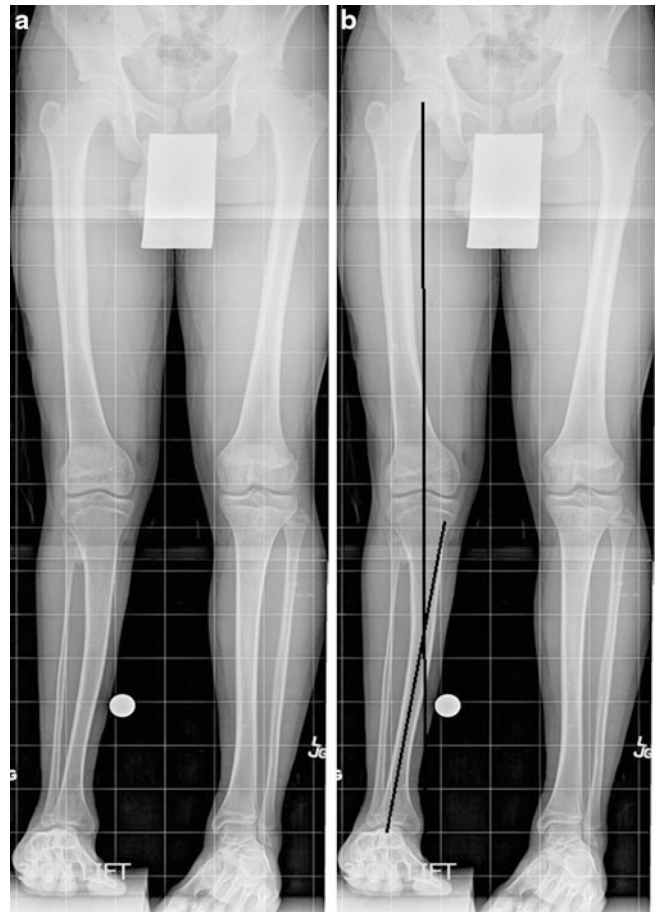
(a) Bipedal erect leg X-ray showing valgus deformity of the tibia, LLD of 3.5 cm, and a short hypoplastic fibula. (b) Surgical planning to determine location of osteotomy and the magnitude of the deformity
